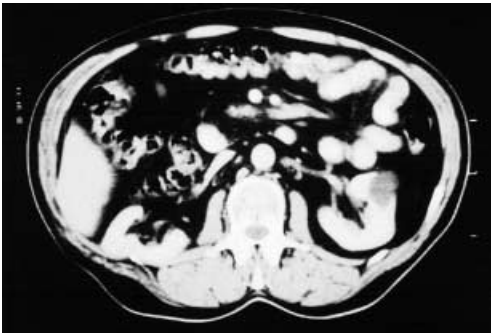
The follow-up CT scan 3 months later was normal as well as the follow-up CT scan 1 year later.
